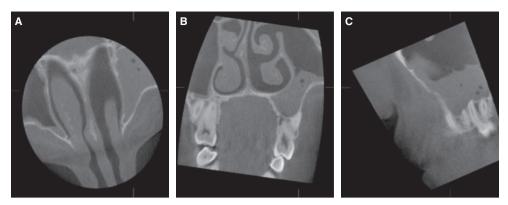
Representative cone-beam computed tomography scans of mixed findings in a 13-year-old male patient: (A) axial scan; (B) coronal scan; and (C) sagittal scan. The right sinus presents a flat mucosal thickening and the left sinus shows signs of acute sinusitis.
